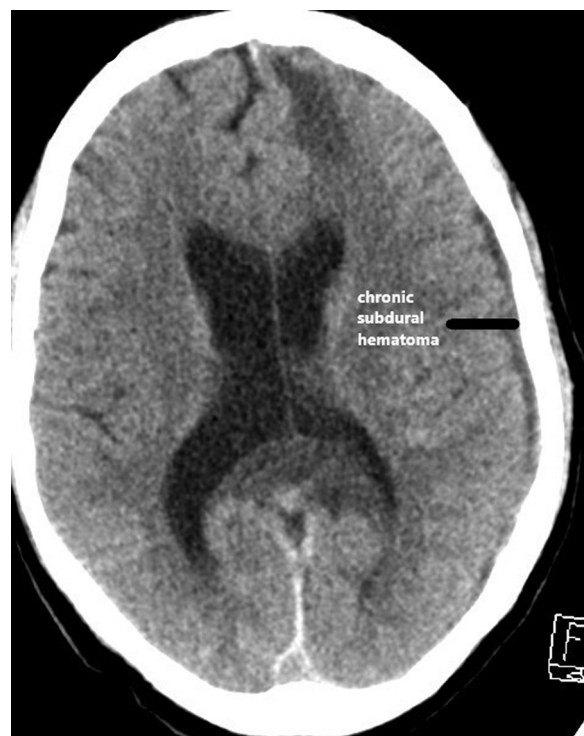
Computed tomography scan of head on day 6 showing resolving and chronic subdural hematoma with resolving subarachnoid hemorrhage.
